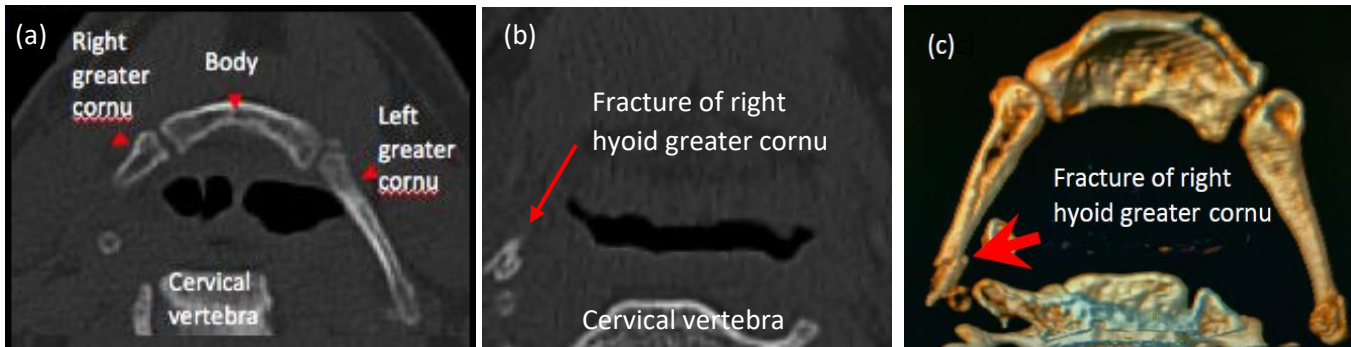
PMCT hyoid (bone window) (a) a more superior and (b) more inferior CT axial slice: Because the head was tilted, the hyoid bone was visualized in different thin (1 mm) axial slices. (c) Three dimensional PMCT volume rendering allowed reconstruction of the hyoid bone, demonstrating the fracture more clearly.
